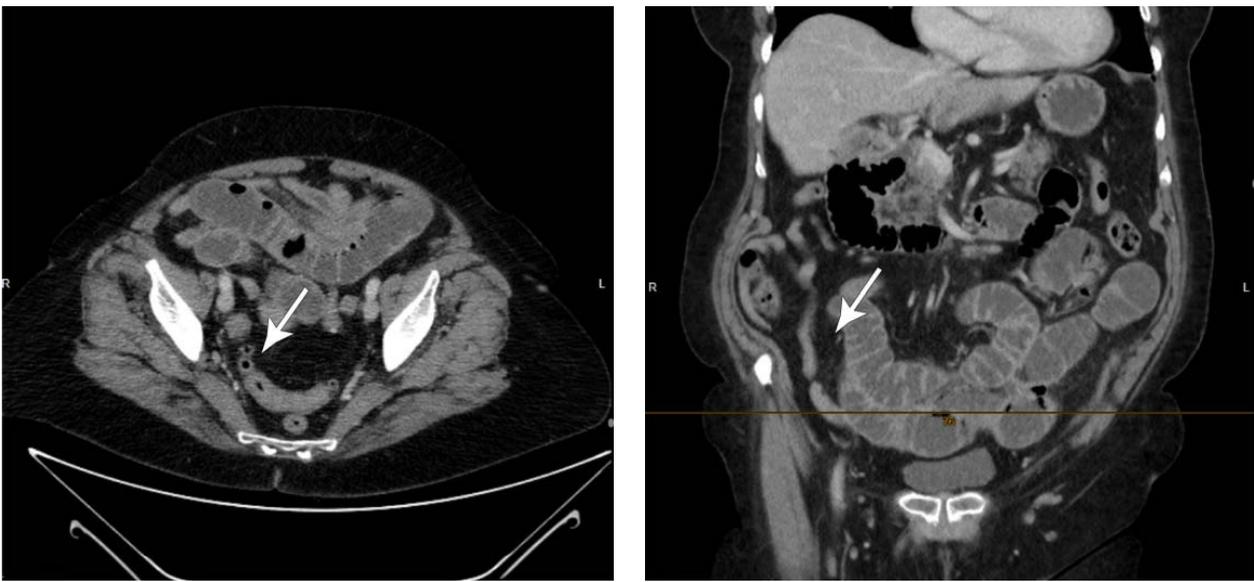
Abdominal CT findings of small bowel ileus (caliber leap of the proximal jejunum as indirect stone evidence, starvation bowel, small bowel ileus, and collapsed colon frame are indicated by arrows)
